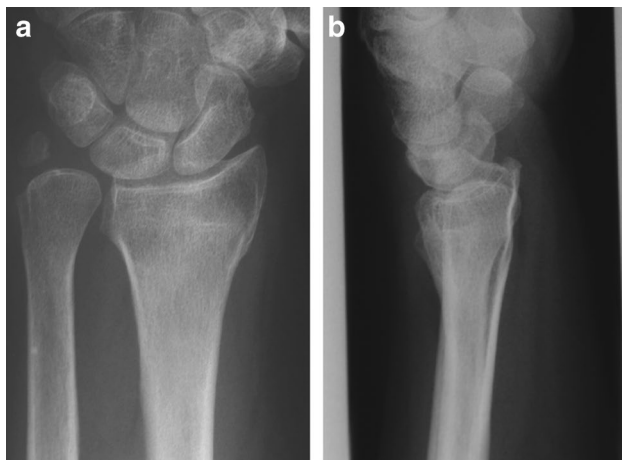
X-ray of a wrist with a distal radius fracture that has healed in malalignment with a dorsal tilt of 30° and an ulna plus situation of 2 mm, a PA radiograph b lateral radiograph
